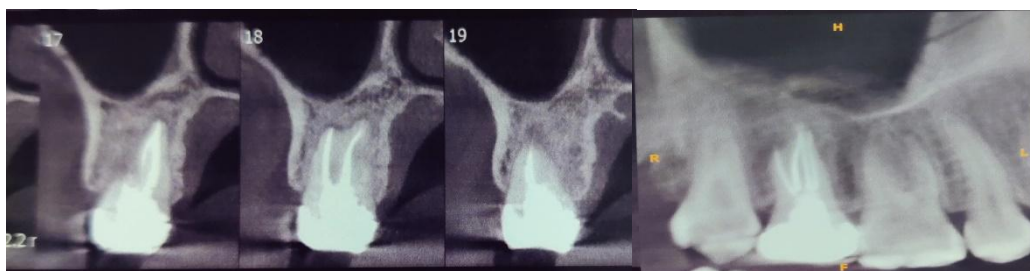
post- operative CBCT images
